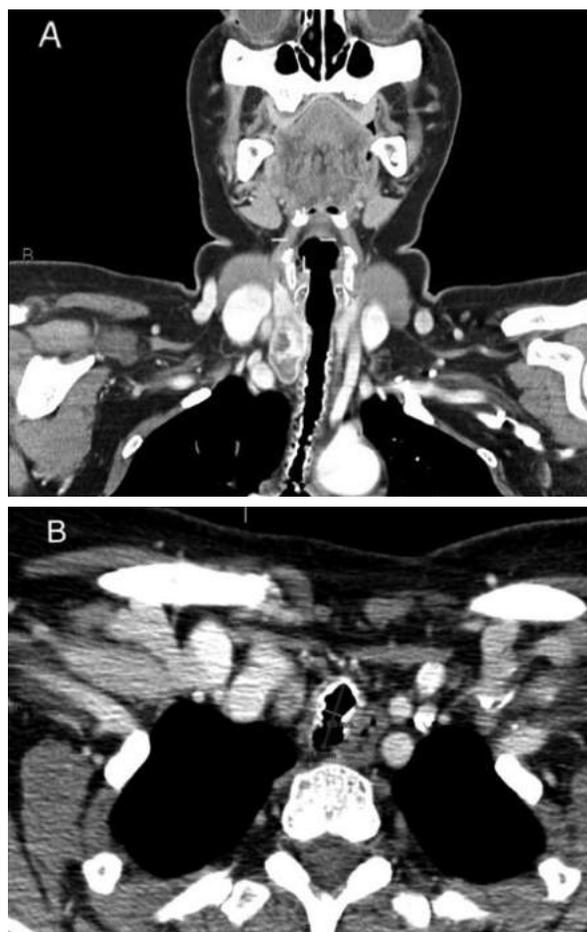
Saber-sheath deformity of the trachea; computed tomography scans: A) axial view, B) coronal view
